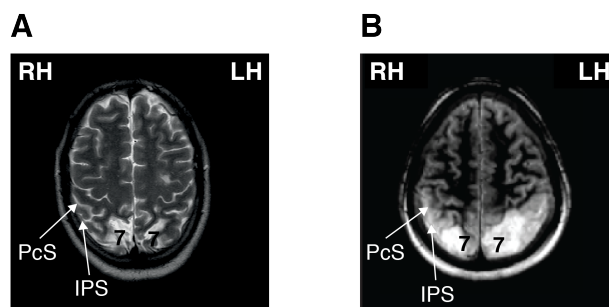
A. Magnetic resonance imaging scan of patient CF. The white areas at the bottom of the scan show asymmetrical lesions to the occipito-parietal region, especially around Brodmann's area 7. The damage is larger in the right than in the left hemisphere. B. Magnetic resonance imaging scan of patient IG. The lesion is fairly symmetrically located in the posterior parietal and upper and lateral occipital cortico-subcortical regions. LH : left hemisphere, RH : right hemisphere, PcS : postcentral sulcus, IPS : intraparietal sulcus.
